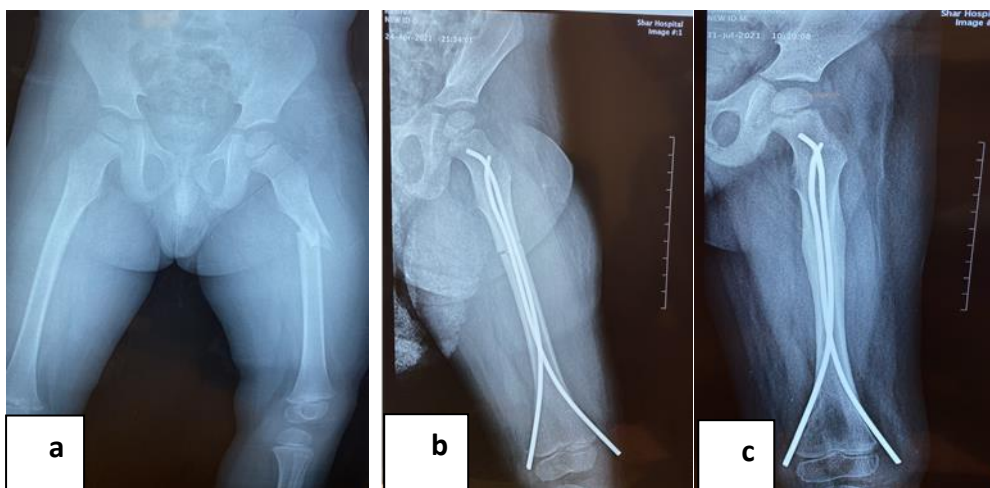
Shows a. Pre-operation x-ray, b. One-day post-operation, and c. After Eight weeks.
